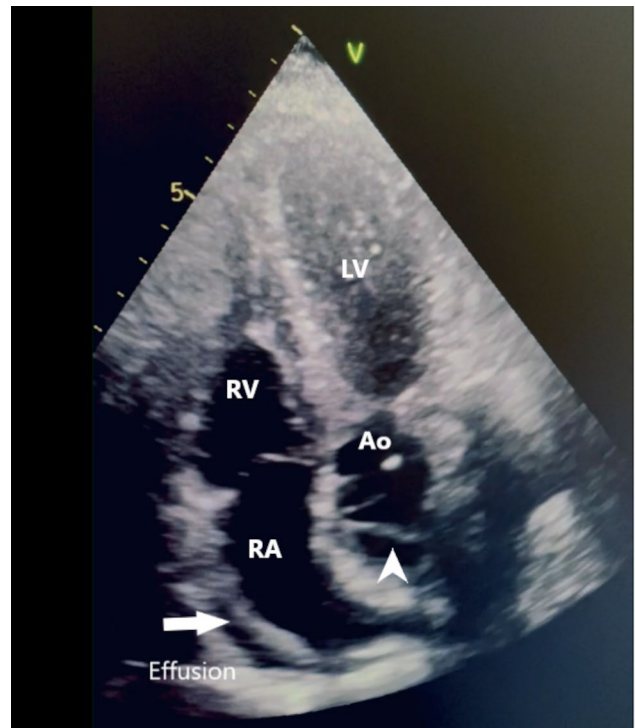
Point-of-care echocardiography in modified apical view: accumulation of fluid in the pericardial sac at the right atrium of the heart (white arrow) and intimal delamination within the ascending aorta (white pointer)
